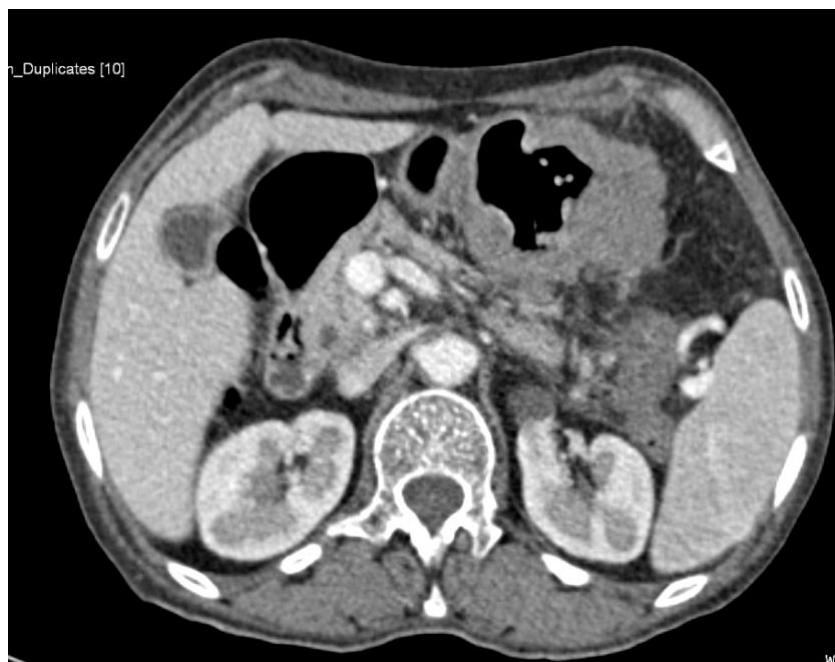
Axial slice of an abdominal CT scan in the portal phase, with the splenic nodule corresponding to the metastasis faintly visible. The gastric NET is also visible.
